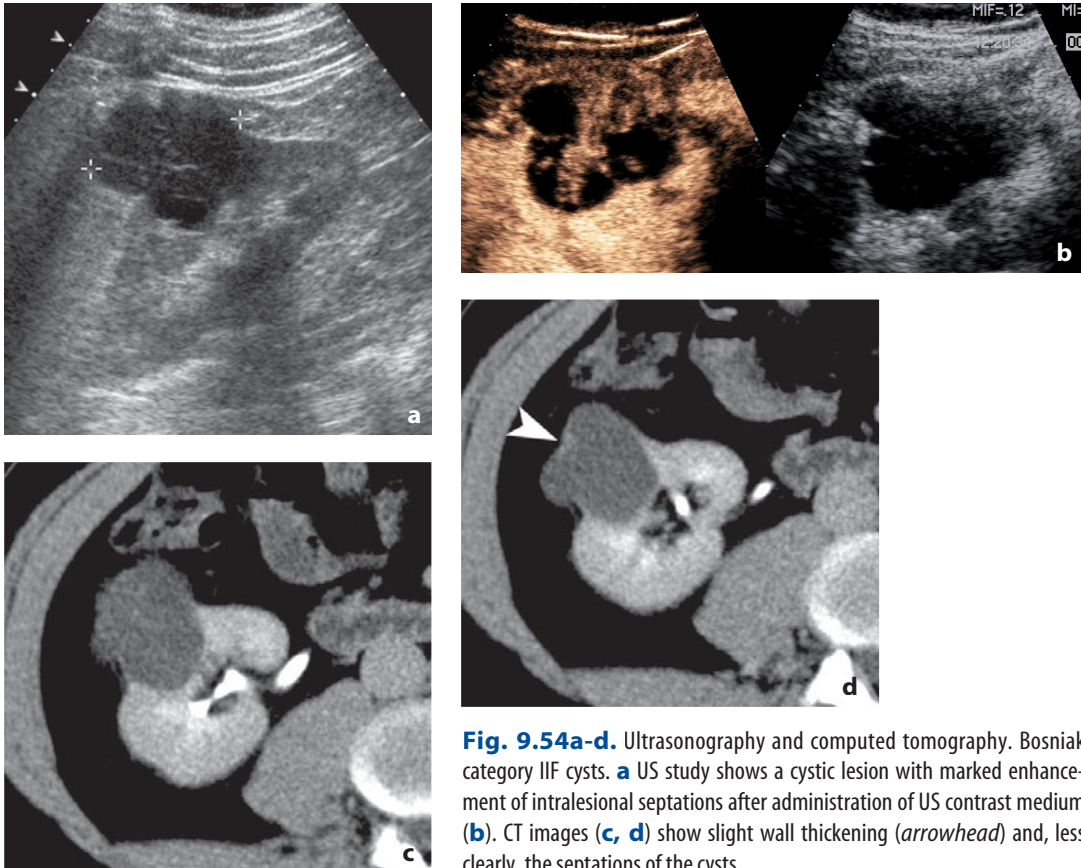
Ultrasonography and computed tomography. Bosniak category IIF cysts. a US study shows a cystic lesion with marked enhancement of intralésional septations after administration of US contrast medium (b). CT images (c, d) show slight wall thickening (*arrowhead*) and, less clearly, the septations of the cysts
